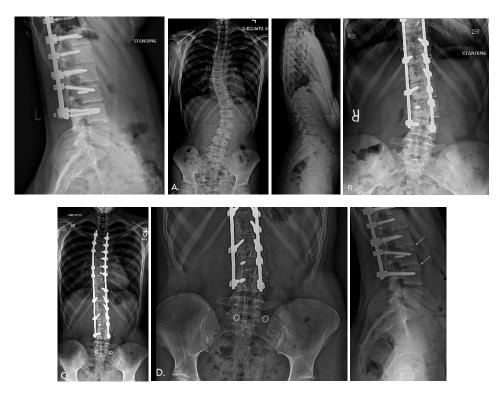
(A) Anteroposterior/lateral radiograph of a 13-year-old skeletally immature girl with 35°/49° curve treated with PSIF to L3, with subsequent adding-on phenomenon and screw fracture at LIV 2 years postoperatively, revised to L4. (B) At the age of 19 years, increased LBP, screw cap dislodgement, and L3-L4 nonunion, are associated with an 18° tilt of the LIV. (C, D) Reinsertion of caudal screws and then two-level X-LIF to restore coronal and sagittal balance, and obtain anterior fusion.
